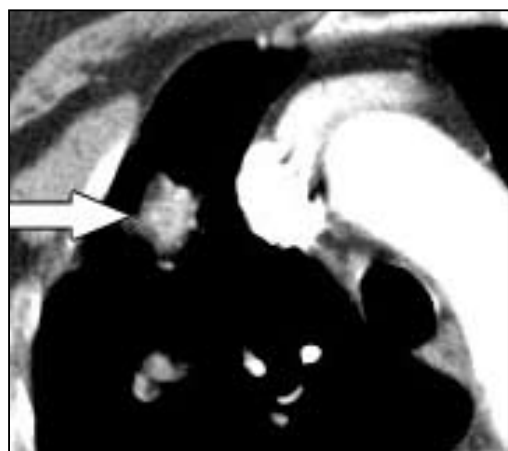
Contrast enhanced CT image performed 3 months after the postablation PET/CT scan shows focal enhancement in the anterior aspect of the ablation cavity (arrow) corresponding to the area of more focal intense activity seen on the prior PET/CT. This area on biopsy showed recurrence of adenocarcinoma.
